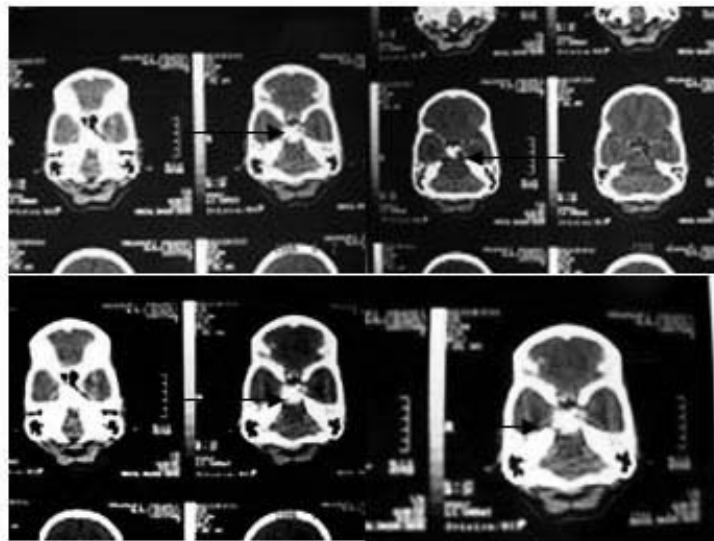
Brain CT scan 6 months after radiation therapy shows tumor mass reduction (arrows) on all pictures.
